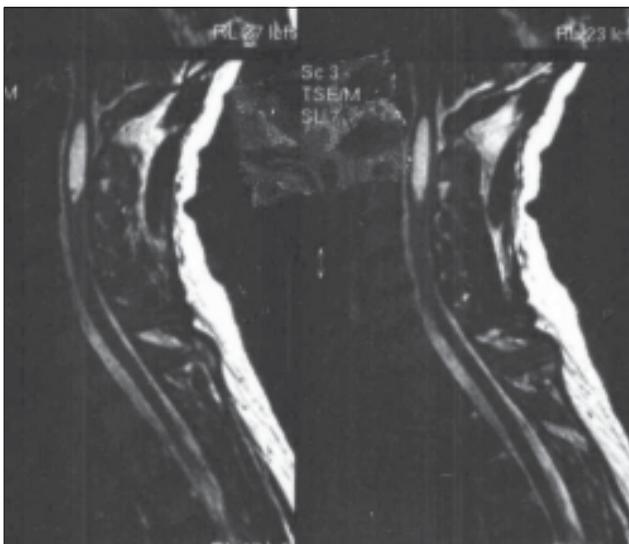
MRI of cervical spine T2
